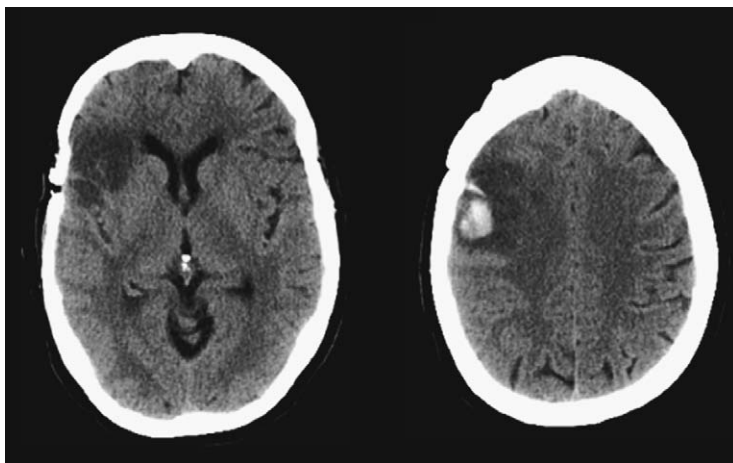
These axial images from a noncontrast head CT scan reveal a wedge-shaped region of low attenuation in the right frontal lobe with a focal intraparenchymal hemorrhage at the superior margin. These images, consistent with a hemorrhagic transformation of a subacute infarct, were taken from a 65-year-old woman who had a history of TIAs and who presented with a right facial droop and slurred speech.
